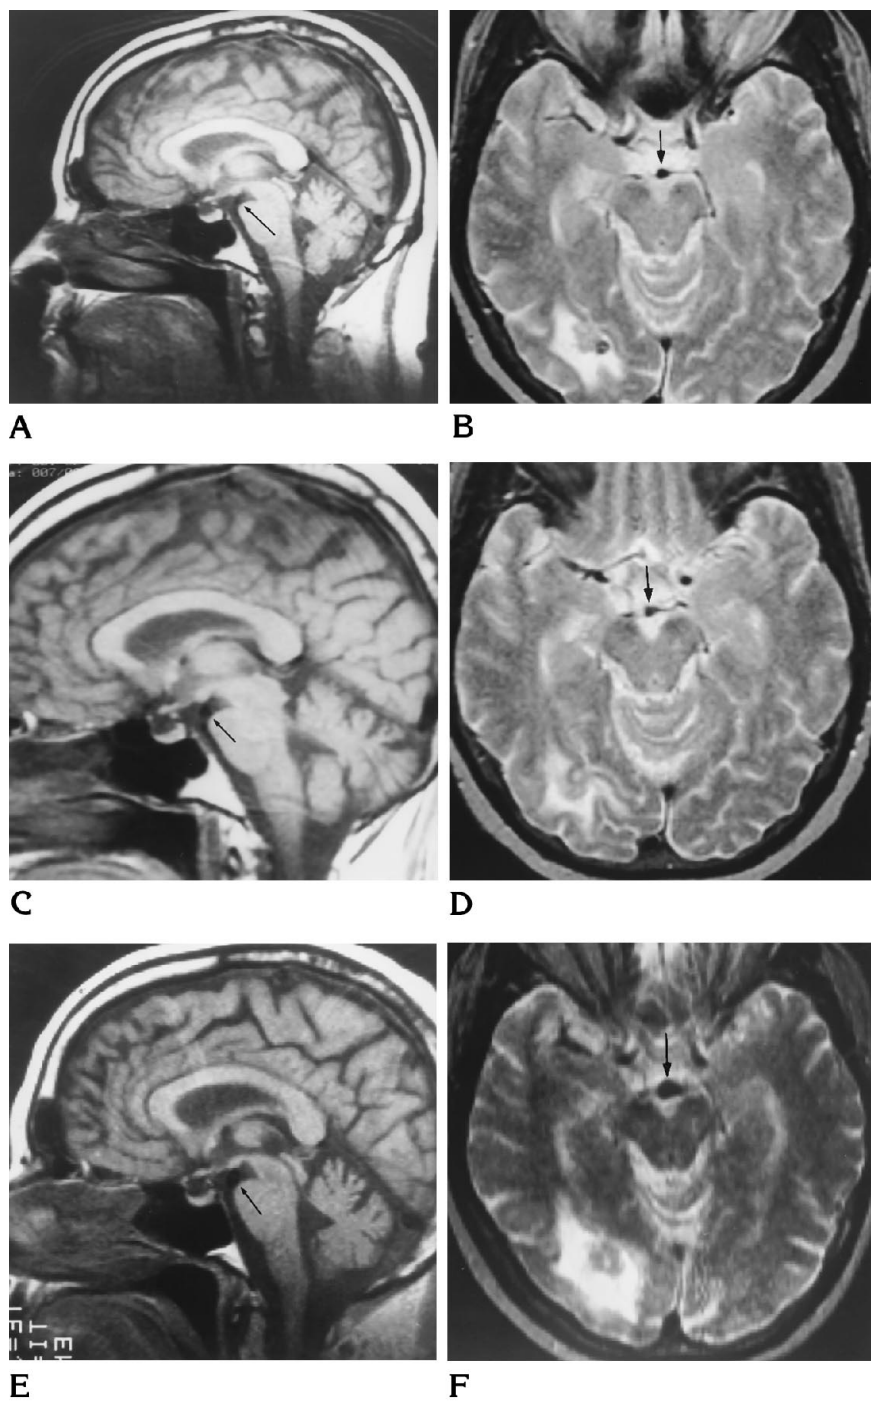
A and B, Sagittal T1-weighted (500/20 [repetition time/echo time]) (A) and axial T2-weighted (2000/80) (B) MR images obtained 7 months antemortem show a normal-appearing tip of the basilar artery (arrows). The T2-weighted image also shows a metastatic focus with surrounding edema in the right parietooccipital lobe.
